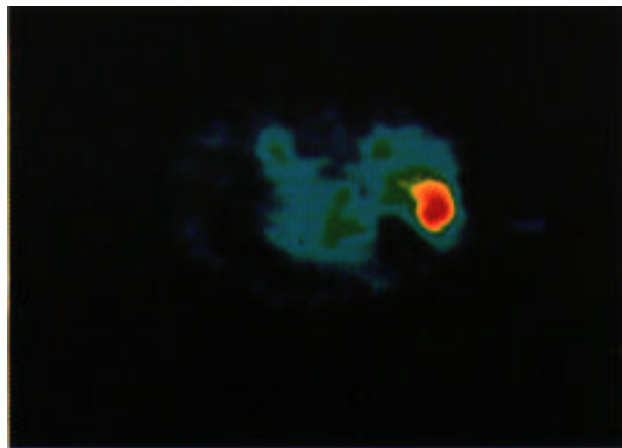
(a) X-CT of a pancreatic cancer with liver metastasis. Low density area in the liver found to be a liver metastasis. (b) Positron tomogram of this case 50 min after ^{18}F FDG injection. The activity of the metastatic liver tumor was much higher than that of primary pancreatic tumor.
